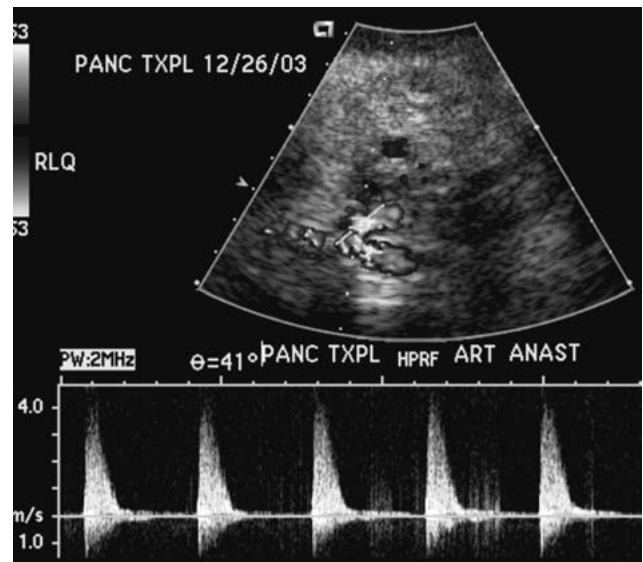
Doppler study of Y graft at anastomosis shows an arterial velocity of 350 cm/s. The patient had no adverse clinical outcome. On follow-up US (not shown) an anastomotic velocity of about 100 cm/s was noted.
